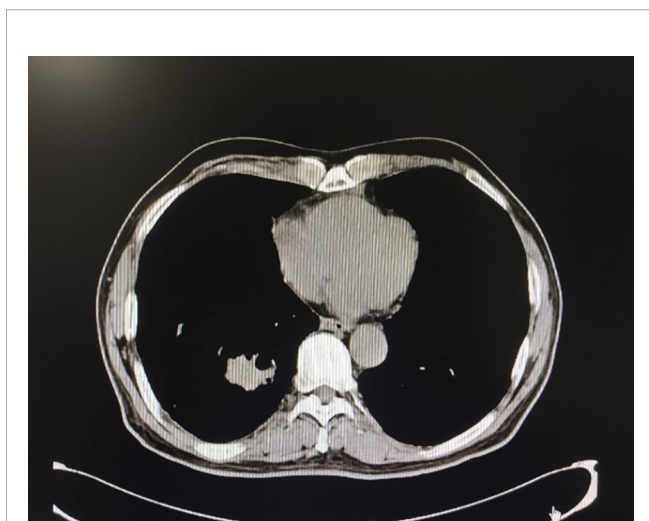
Chest CT after nine cycles of treatment, the space-occupying mass in the lower lobe of the right lung was significantly reduced.
